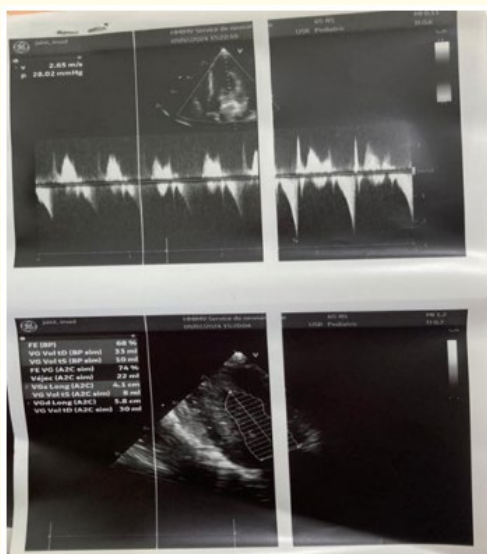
Transthoracic ultrasound showing coarctation of the aorta.
